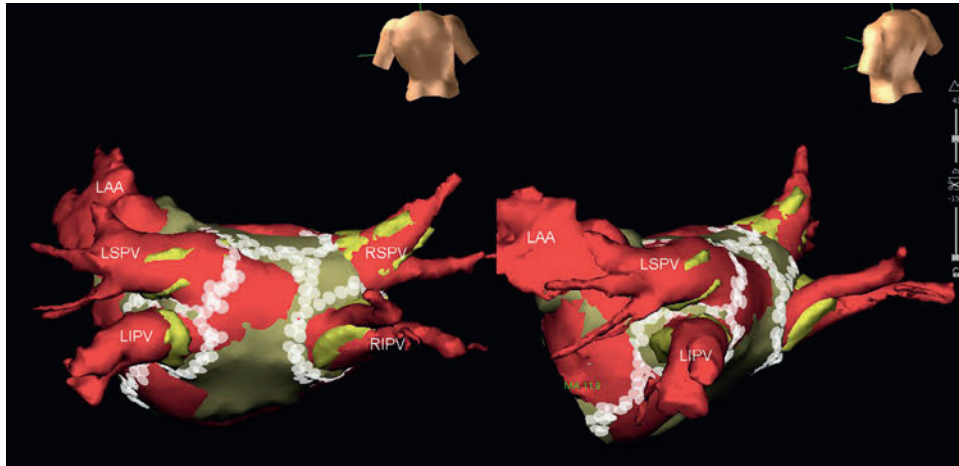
Integration of CT and EnSite NavX Electroanatomic Mapping Data. Shown are posteroanterior (*left*) and left lateral views (*right*) of the electroanatomic contour acquired with catheter manipulation in the left atrium (LA) during atrial fibrillation ablation overlaid on a CT image of the left atrium acquired several days earlier. Small white circles are tagged sites at which radiofrequency energy was applied. Circumferential LA ablation, as well as linear ablation across the LA roof and later mitral annulus, were performed. LAA, Left atrial appendage; LIPV, left inferior pulmonary veins; LSPV, left superior pulmonary veins; RIPV, right inferior pulmonary veins; RSPV, right superior pulmonary veins.
